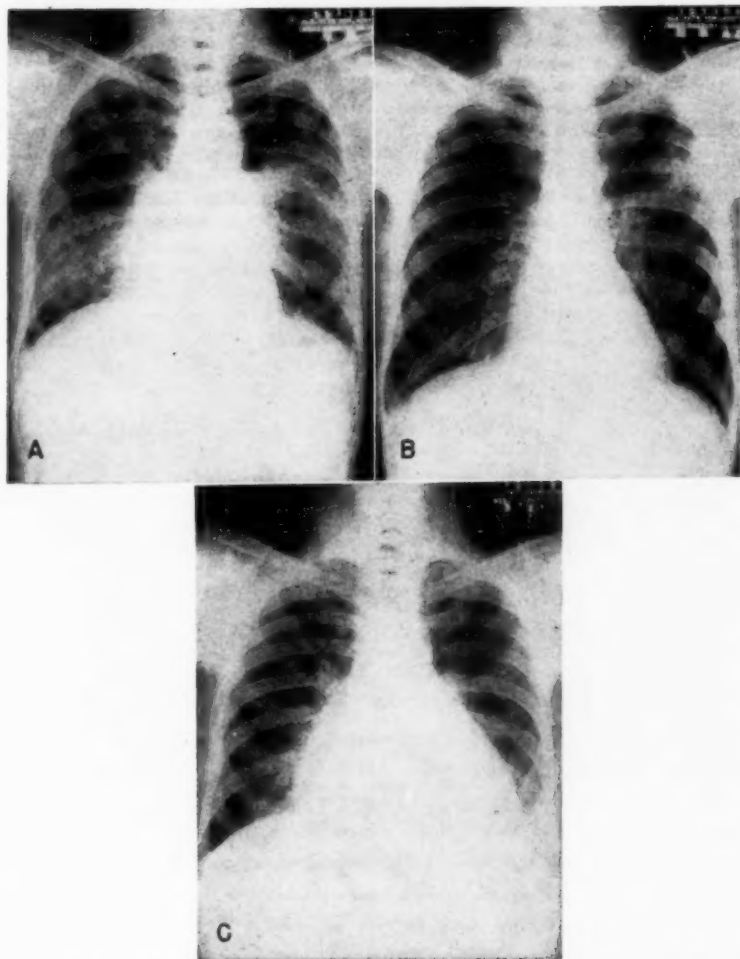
Case 6. Roentgenograms of the chest. A. Extensive pulmonary infiltration extending fan-like from the hilar areas. B. Three months later. Extensive improvement. C. Pericardial effusion, fluid at the left base.
